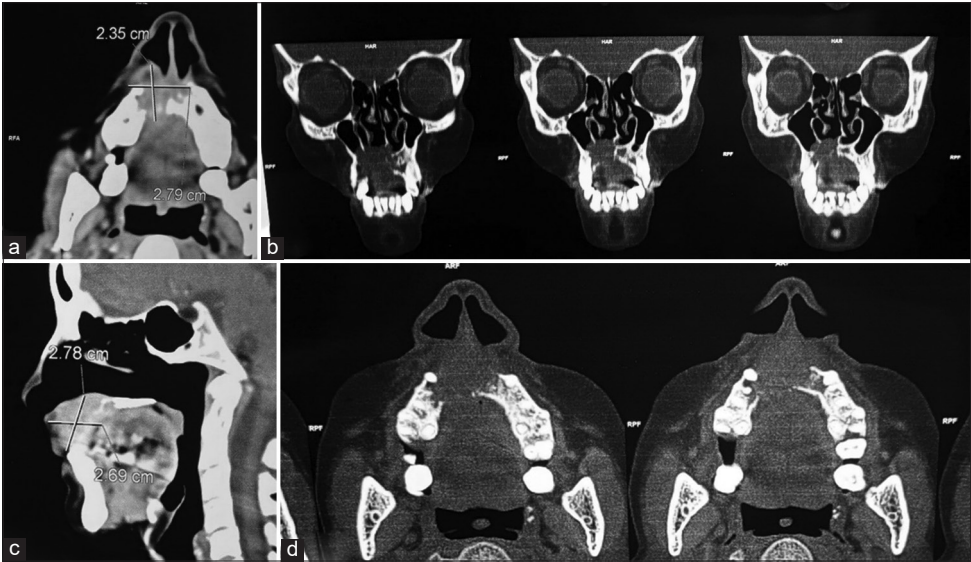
(a-d) Computed tomography coronal (b) axial (a and d) and sagittal (c) sections of the lesion involving the maxillary anterior alveolus and the right maxillary sinus
